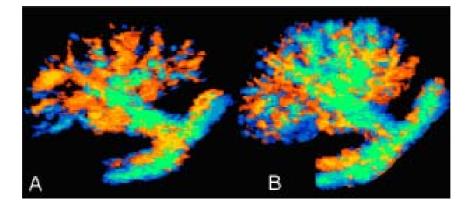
The 3D color Doppler imaging of distribution of renal blood flow signals improved obviously at 10 day after treatment of dialysis. A: before treatment, B: 10 day after treatment.
